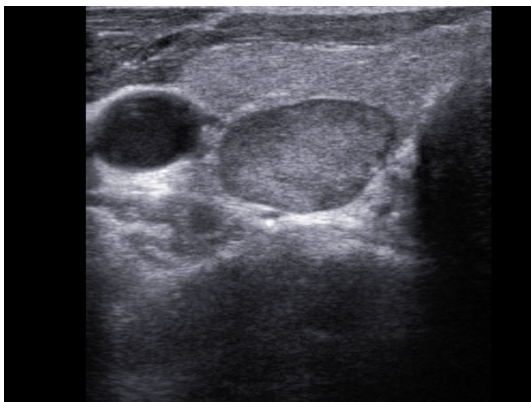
Ultrasonogram shows a hypoechoic solid parathyroid adenoma.
